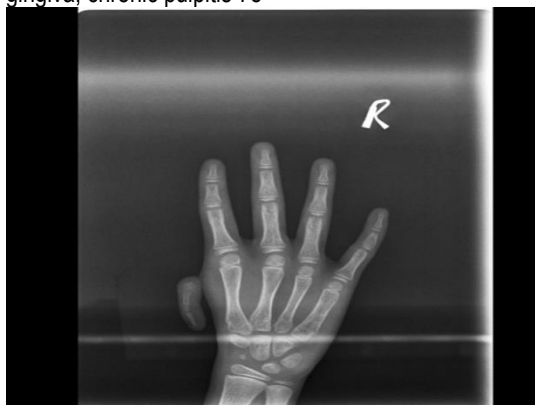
Right hand wrist radiograph showing hypoplastic thumb, rudimentary 5th Meta carpal bond
